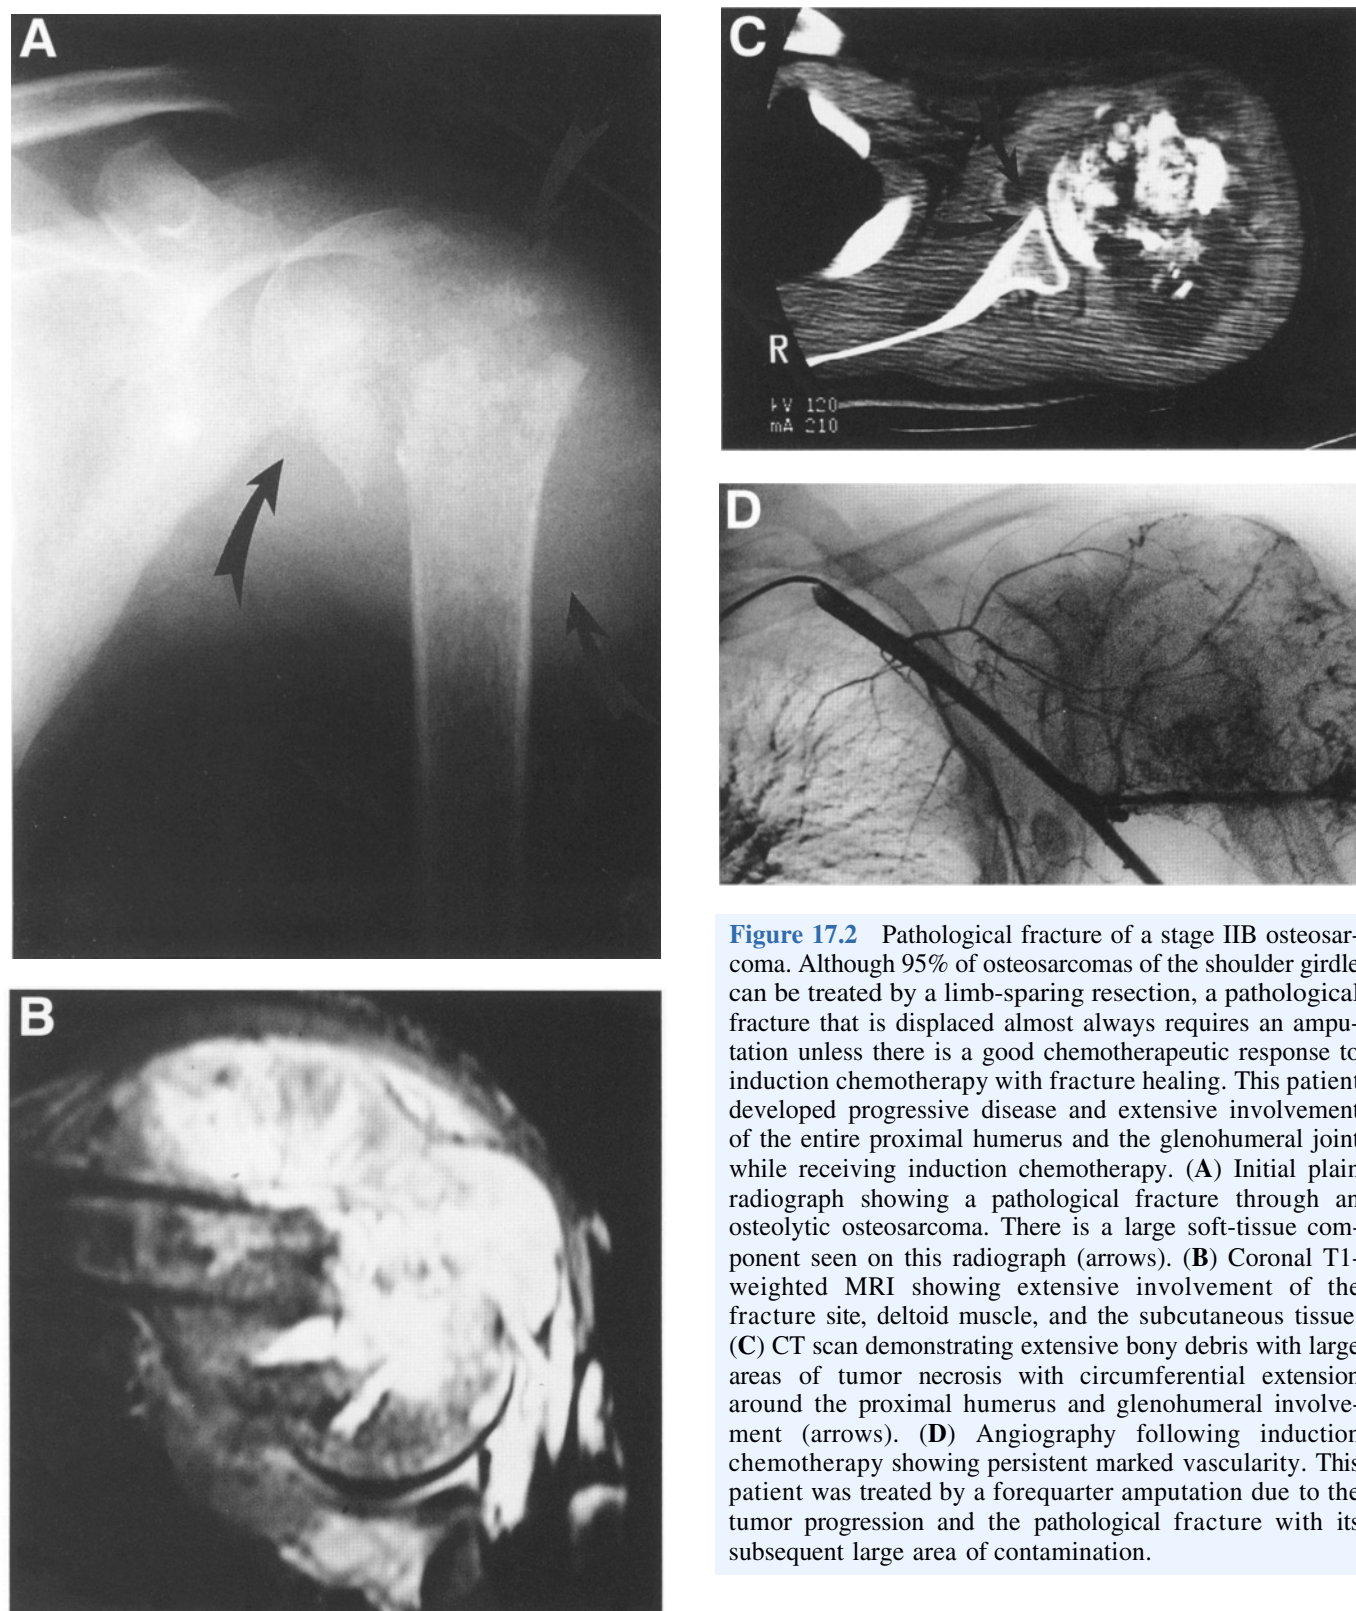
Pathological fracture of a stage IIB osteosarcoma. Although 95% of osteosarcomas of the shoulder girdle can be treated by a limb-sparing resection, a pathological fracture that is displaced almost always requires an amputation unless there is a good chemotherapeutic response to induction chemotherapy with fracture healing. This patient developed progressive disease and extensive involvement of the entire proximal humerus and the glenohumeral joint while receiving induction chemotherapy. (A) Initial plain radiograph showing a pathological fracture through an osteolytic osteosarcoma. There is a large soft-tissue component seen on this radiograph (arrows). (B) Coronal T1-weighted MRI showing extensive involvement of the fracture site, deltoid muscle, and the subcutaneous tissue. (C) CT scan demonstrating extensive bony debris with large areas of tumor necrosis with circumferential extension around the proximal humerus and glenohumeral involvement (arrows). (D) Angiography following induction chemotherapy showing persistent marked vascularity. This patient was treated by a forequarter amputation due to the tumor progression and the pathological fracture with its subsequent large area of contamination.
